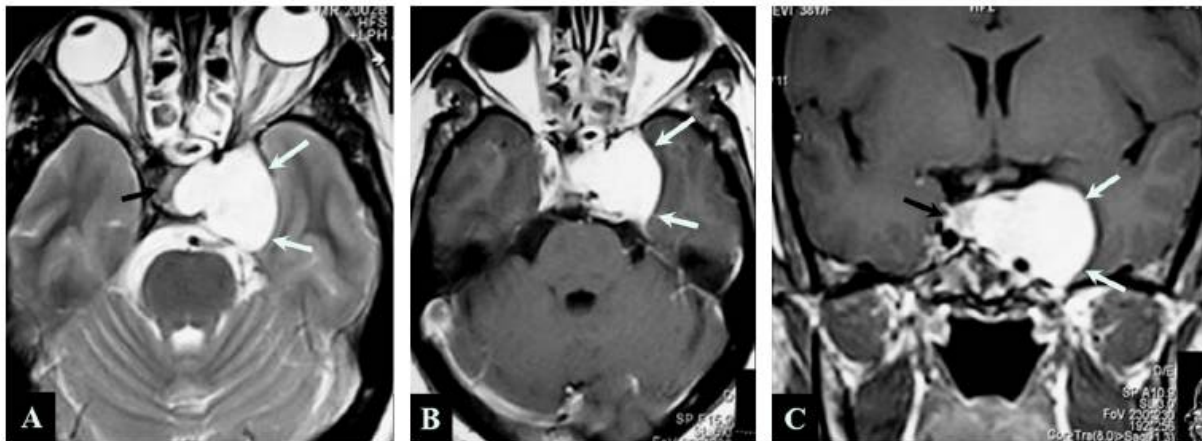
imaging of lymphoma. Axial CE T1W and T2 weighted MR images shows homogeneous contrast enhancement of the tumor (arrowhead). (67)
